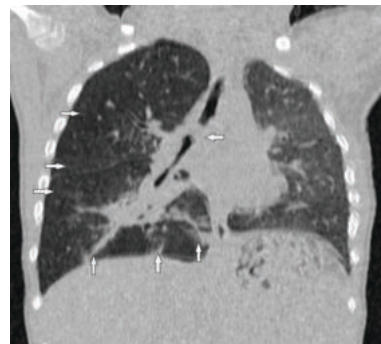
Three dimensional coronal reformatted CT image showing
